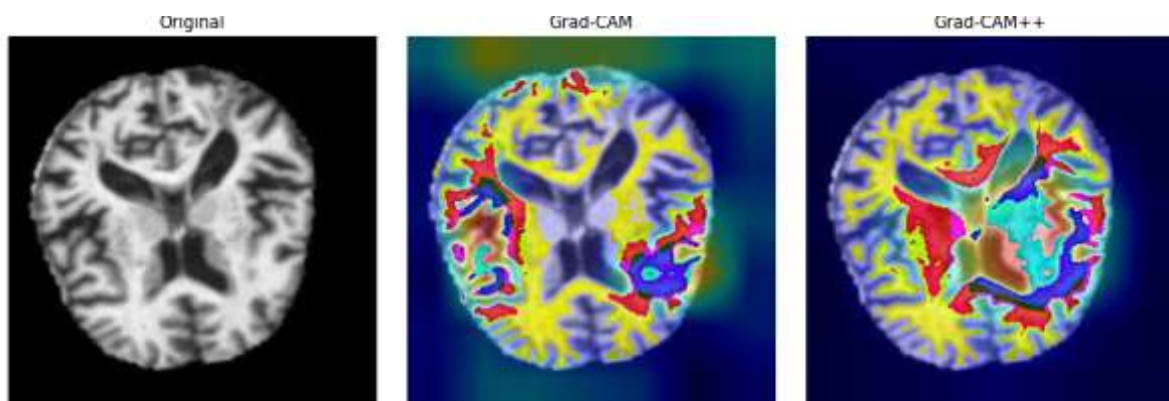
Grad-CAM and Grad-CAM++ visualization for a second representative Alzheimer's MRI slice using MobileNetV2.
